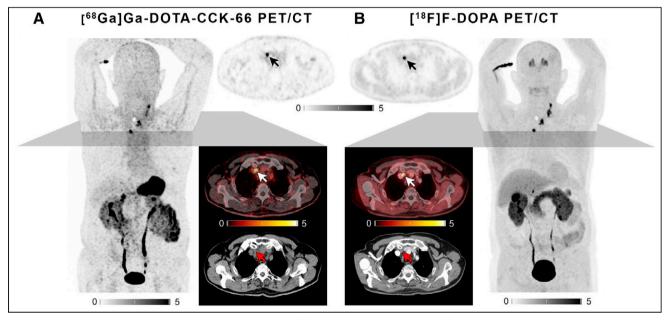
Maximum-intensity projections and axial sections of [⁶⁸Ga]Ga-DOTA-CCK-66 (A) and [¹⁸F]F-DOPA (B) PET/CT. White stars indicate local tumor in left thyroid bed. Arrows indicate lymph node metastasis in right upper mediastinum. Intensity scale bars are SUV.
